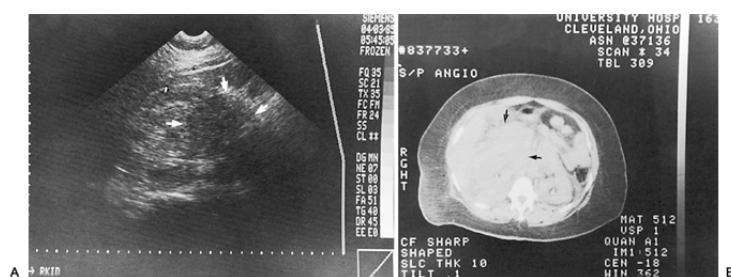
21. A: Large perirenal hematoma after blunt abdominal trauma (*arrows*). B: Computed tomography scan of same patient.
